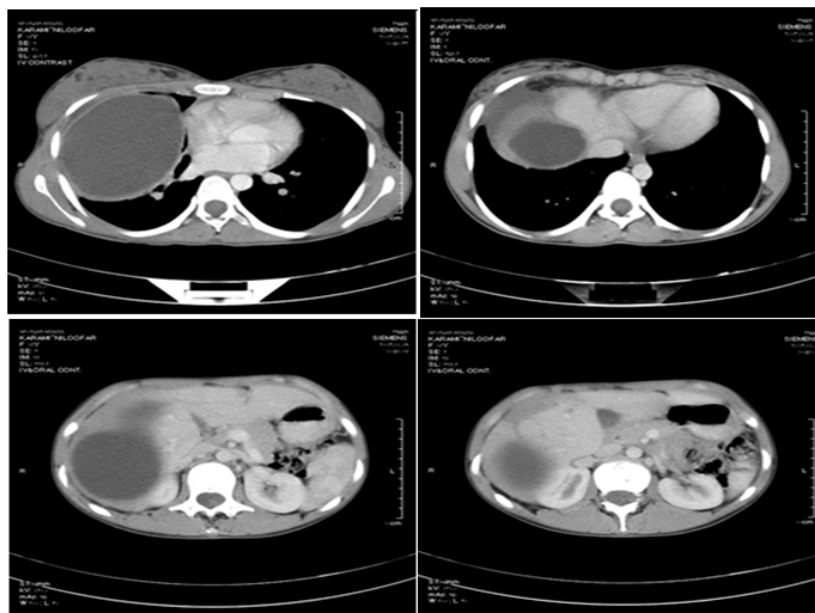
Different sections of thorax and abdomen CT scan
